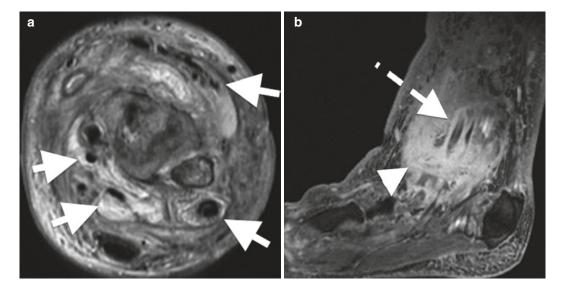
MRI of the infected tenosynovitis, (a) axial T2FS and (b) Sag T1FS PG demonstrate extensive fluid SI distension of the tendon sheaths proximal to the ankle (*arrows*) in (a) and post-gadolinium enhancement (*dashed*
